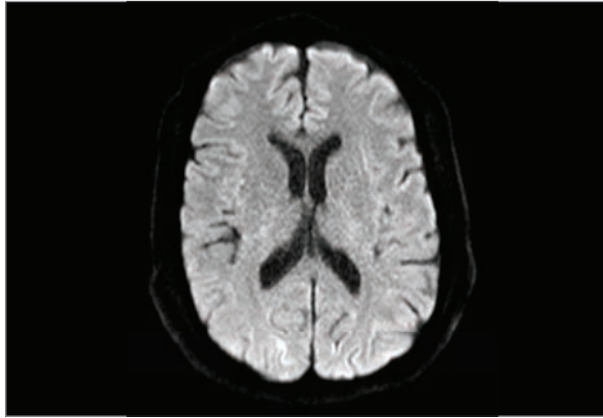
Diffusion-weighted imaging axial magnetic resonance imaging brain 3 days after symptom onset with very subtle evidence of areas of diffusion restriction in the bilateral occipital lobes. There was no posterior cortical atrophy or other abnormality.
